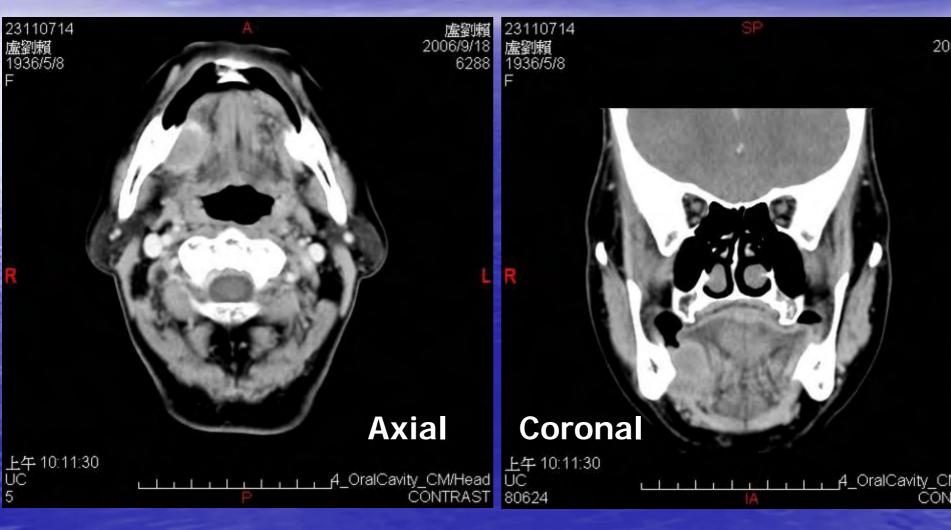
Image finding – CT of Oral Cavity (95/09/22)
